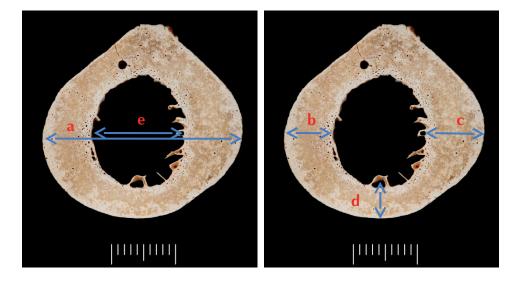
Measures of femur mid-shaft on radiographs (anterior-posterior view): a = maximum medio-lateral width, b = lateral cortex, c = medial cortex, e = medulla medio-lateral width; (lateral view): d = anterior cortex.
